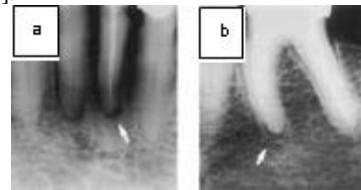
Example of Periapical Radiolucency [13]
